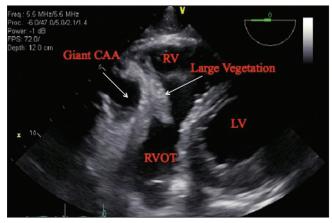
Transesophageal echocardiogram: A giant CAA is noted exterior to the RV (arrow). Large vegetation attached to the RV free wall is also seen (arrow). CAA = Coronary artery aneurysm, RVOT = Right ventricular outflow track
